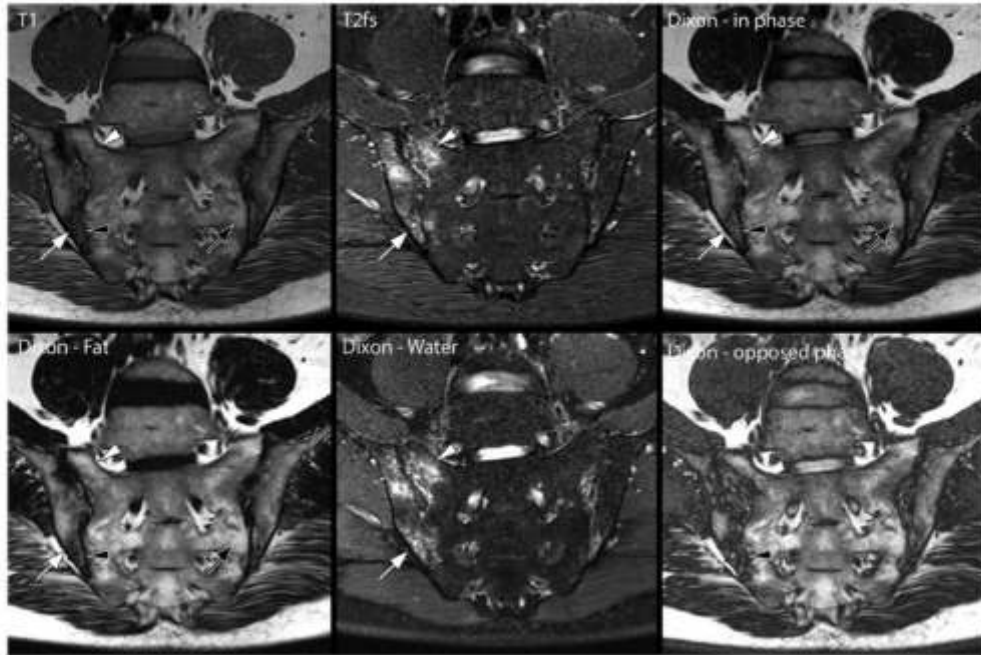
MR image of the sacroiliac joints of a 45-year-old patient with advanced axial spondyloarthritis. One single T2-Dixon sequence with 4 contrasts (in-phase, opposed-phase, and fat and water image) is compared to standard T1 and T2 fat saturation (fs). Bone marrow edema (white arrow, high signal intensity in T2 fs, in-phase and water image, low signal in T1 and fat image) can clearly be differentiated from fat lesions (black arrow, high signal in T1, in-phase, and fat image). Edema within a fat lesion is also visible (white arrowhead). Dixon opposed phase can help detecting erosions (black arrowhead).
